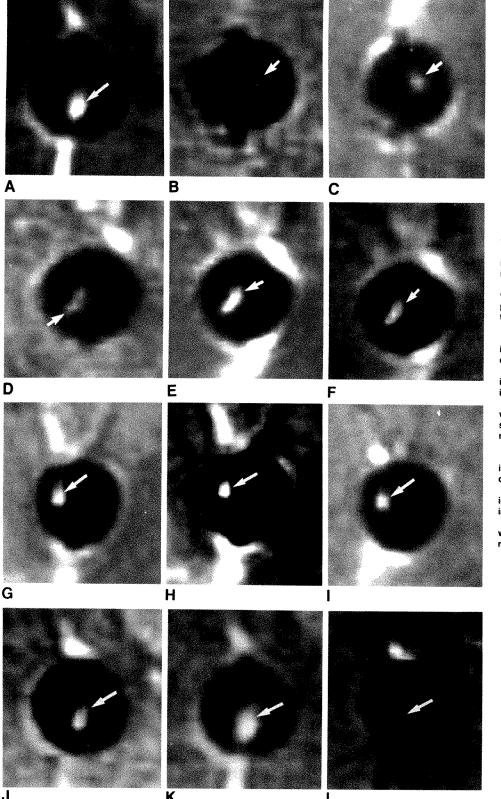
MR images of normal and demyelinated nerves.
